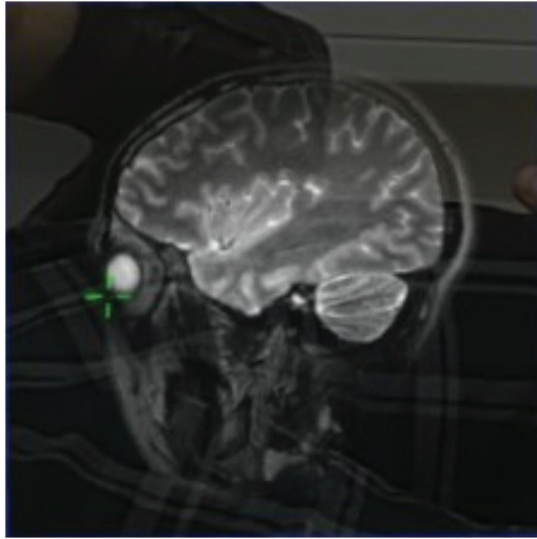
Superimposed representation inside the CAD-software. Corresponding magnetic resonance image with the right eye and the measuring point.
